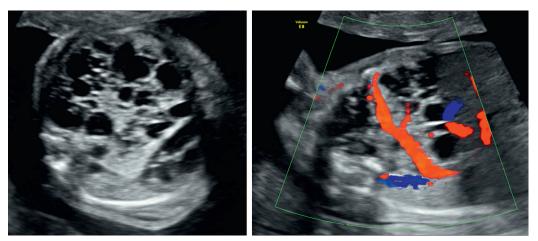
Solid cystic mass in the left lung. Use of color Doppler allows visualization of an arterial supply vessel, which originates directly from the aorta leading to a diagnosis of CCAM-BPS hybrid.
